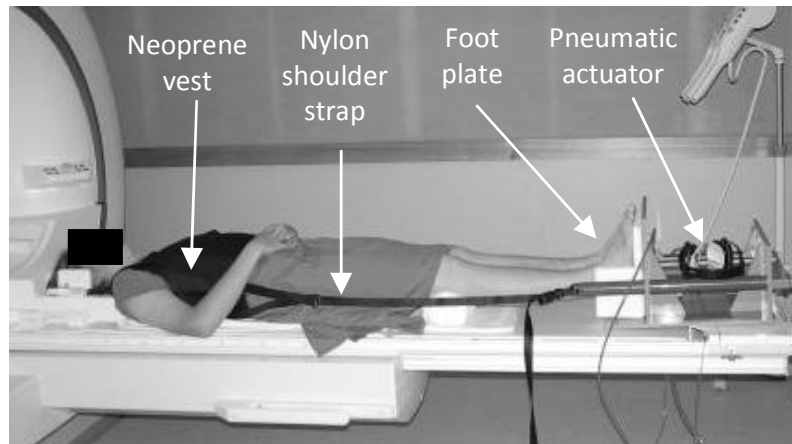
Compression device for axially-loaded MRI of scoliosis subjects
